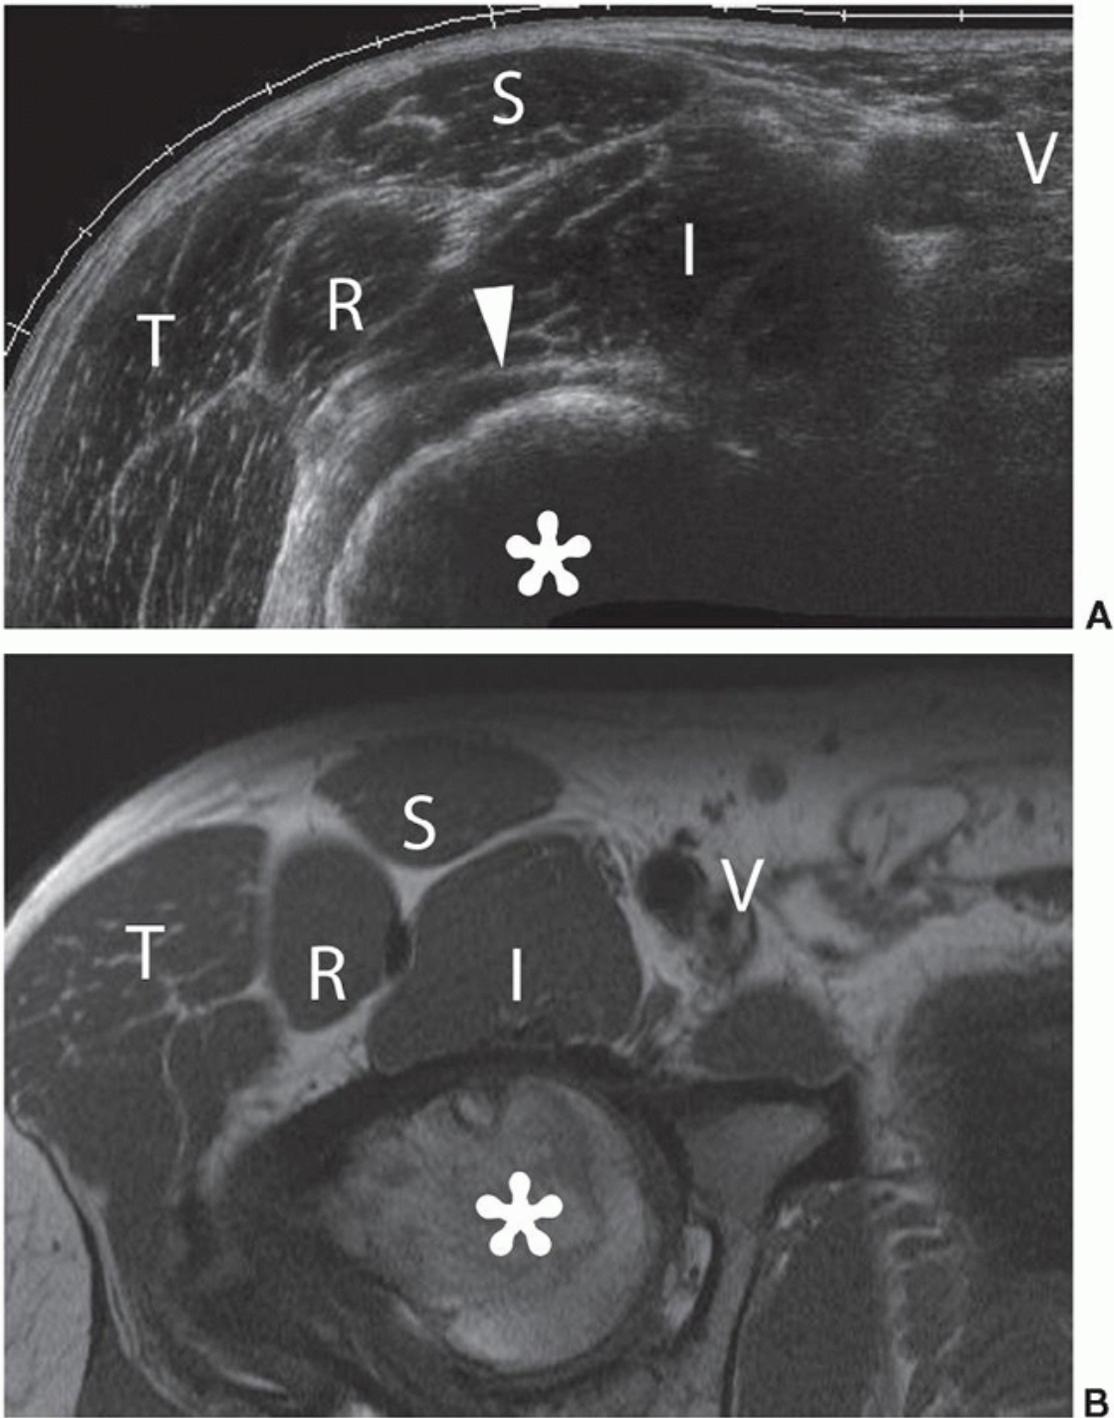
Normal TS views of the hip. A: Transverse sonogram and B: Axial T1W MRI show femoral head (asterisk), iliopsoas (I), TFL (T), rectus femoris (R), sartorius (S), femoral vessels (V), and capsule (arrowhead).
